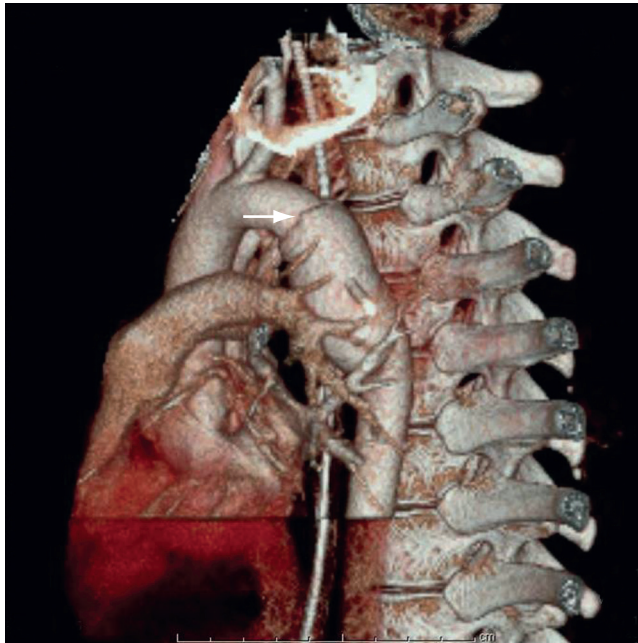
Three-dimensional reconstruction of chest computed tomography (CT) scan showing aortic injury (arrow).
